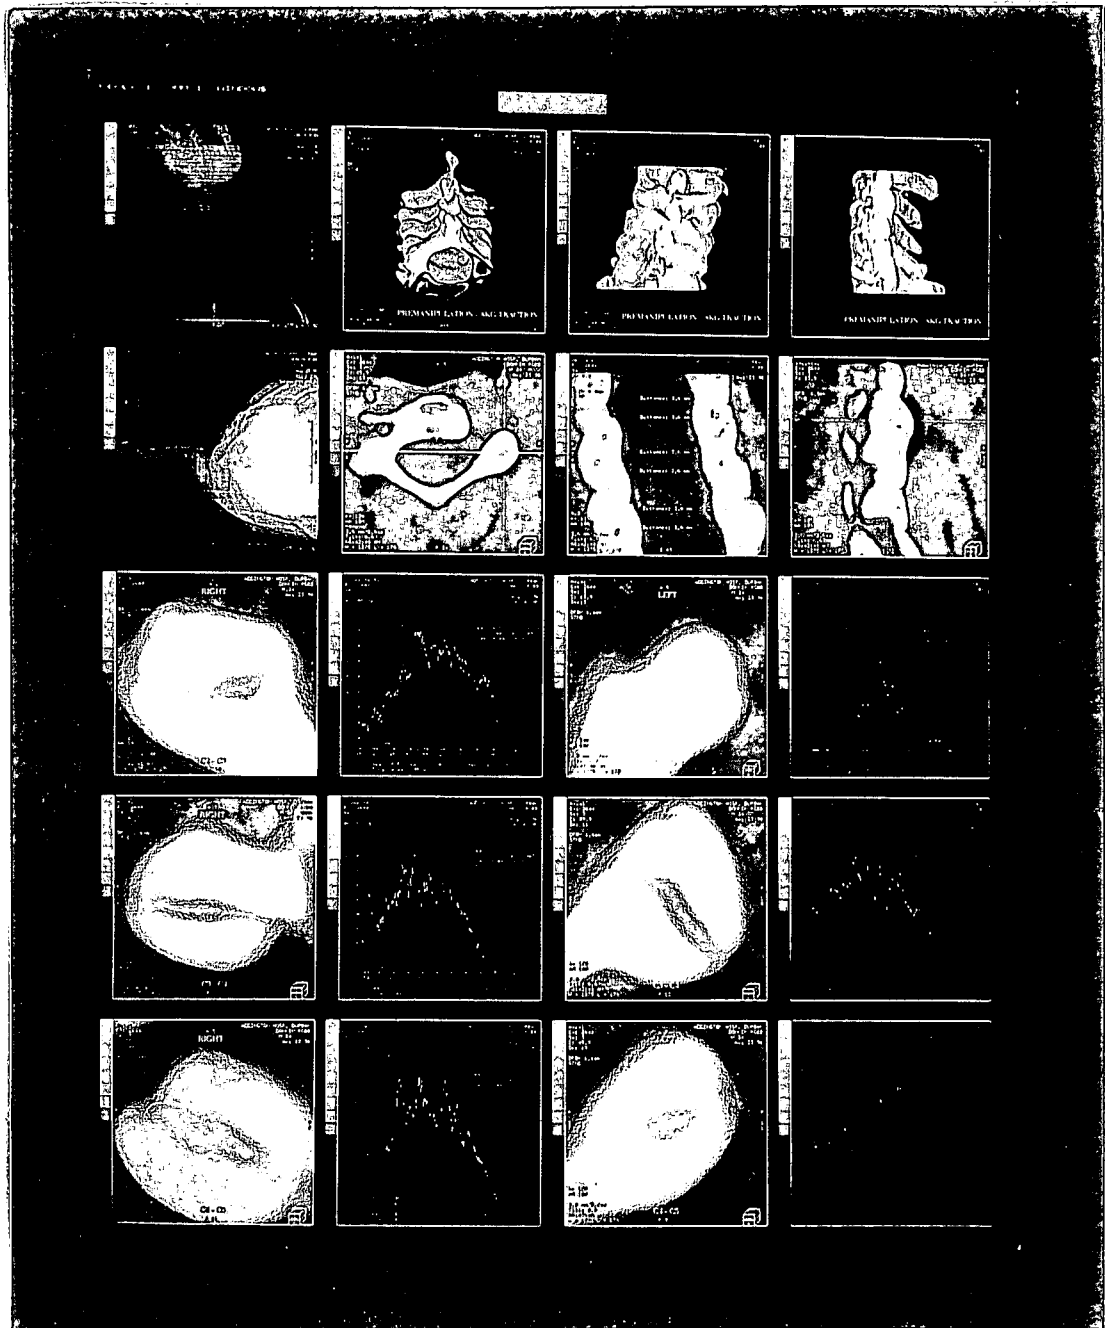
Experiment 5 : Post-manipulation CT scan
